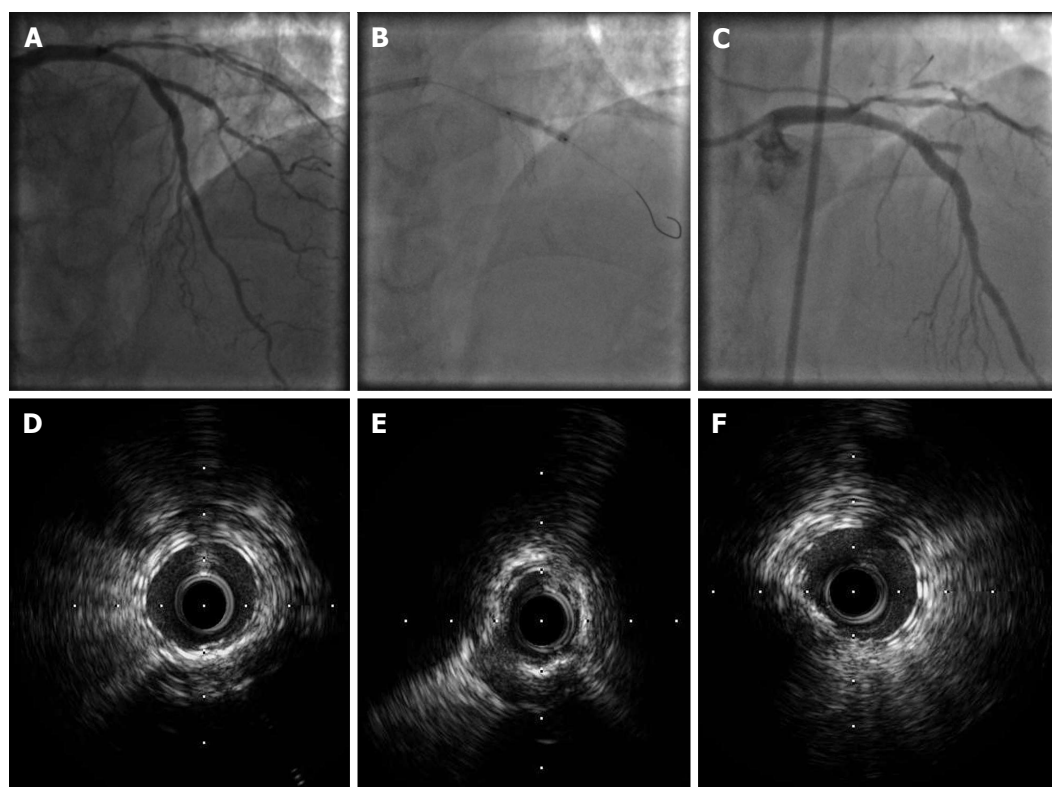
Intravascular ultrasound findings in patient with stent failure. A: Left anterior descending-Diagonal bifurcation treated with everolimus-eluting stent implantation in the left anterior descending and bioabsorbable everolimus-eluting scaffold implantation (T-stenting) in the diagonal branch; B: Post-dilatation with a noncompliant balloon in the diagonal branch; C: Four days later, the patient presented with acute myocardial infarction and stent thrombosis in the diagonal branch; D-E: Post-intervention IVUS showed stent underexpansion in the mid part of the diagonal branch (E) with good stent expansion at the proximal part (D) and at the distal part (F) of the diagonal branch. IVUS: Intravascular ultrasound.
